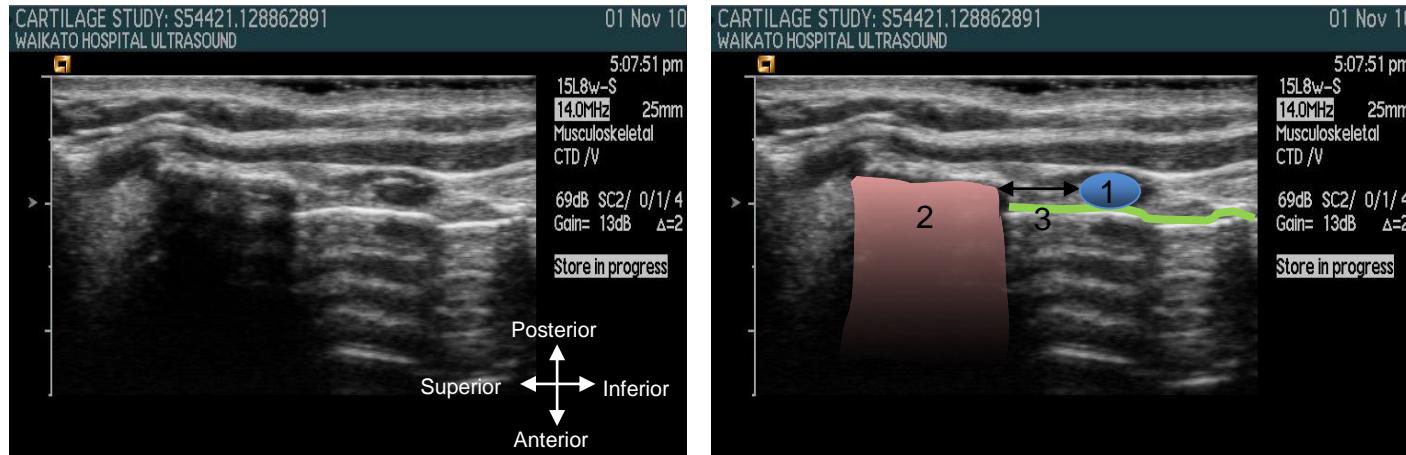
Ultrasound image showing cartilaginous structures of the larynx on sagittal view. The right hand image is a coloured version of the left to highlight anatomical structures. 1. Cricoid cartilage 2. Lower edge thyroid cartilage 3. Tracheal lumen (green line). Arrow: Anterior cricothyroid space. There is a centimetre scale bar on the left of each image (Source: Author)
